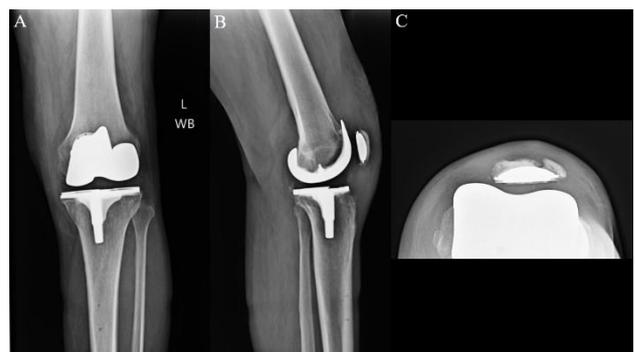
(A) AP, (B) lateral, and (C) sunrise radiographs six weeks post-operatively after patelloplasty.
